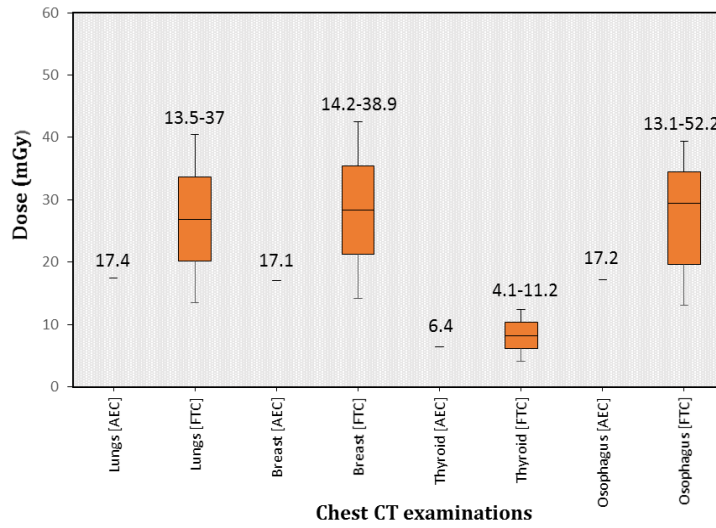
Organ doses for chest computed tomography examinations
